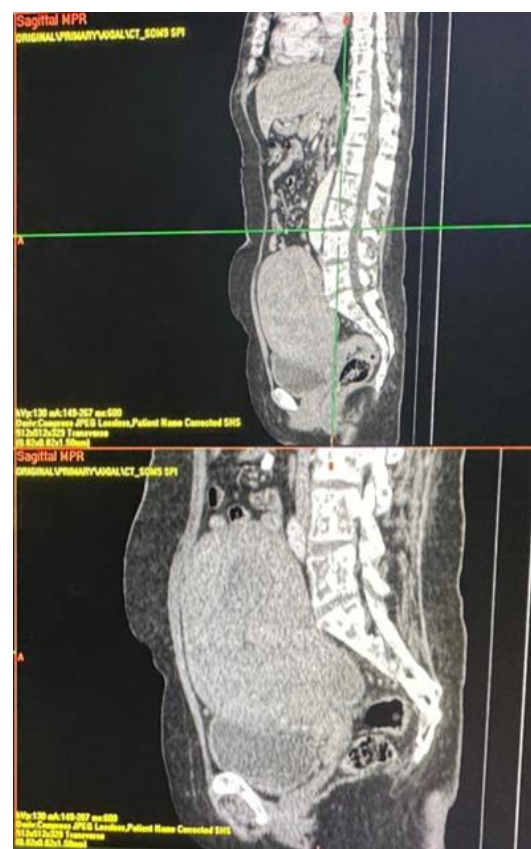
Sagittal slice of an abdominopelvic CT scan showing Globular uterus with lobulated contours, containing multiple lesions
